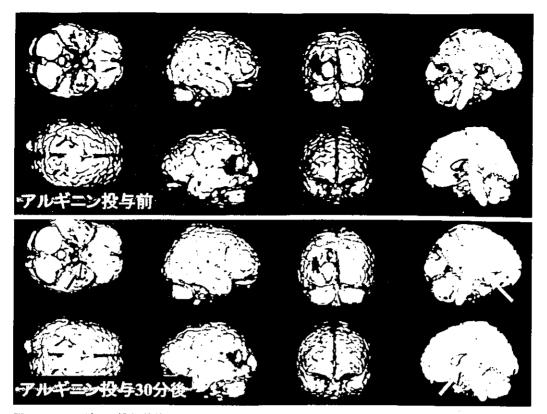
L-アルギニン投与前後の SPM-SPECT 画像
